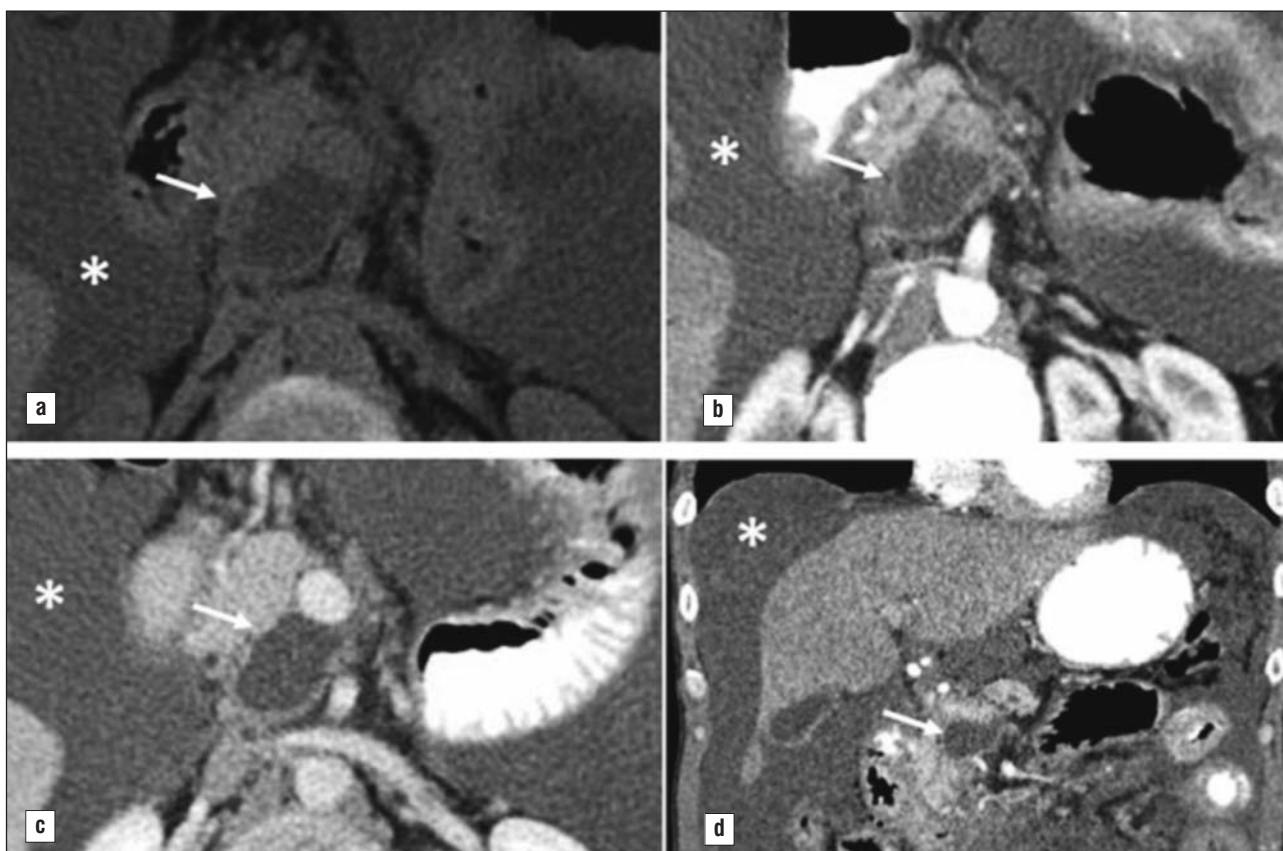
Retrocephalic pancreatic pseudocyst (arrow); Voluminous ascites (asterix) - (a) native CT; (b) CT + contrast, arterial phase; (c) CT + contrast, portal phase; d) coronal reconstruction CT + contrast arterial phase
